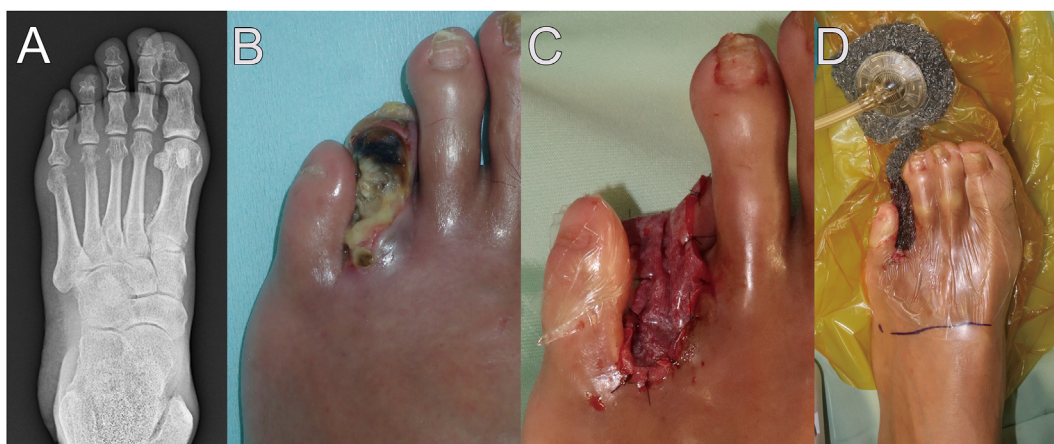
Preoperative X-ray image and intraoperative findings during the treatment of the left necrotic fourth toe of a 58-year-old male with critical limb ischemia. A. X-ray image of the left foot revealed the destruction of distal phalanx of the fourth toe. B. The left fourth toe found to be necrosis. C. After the distal part of metatarsal bone of fourth toe was amputated under local anesthesia, human recombinant basic fibroblast growth factor was sprayed, and artificial dermis was grafted onto the wound site with 5-0 nylon. D. The artificial dermis was fixed using NPWT with “Elephant-trunk” technique.
